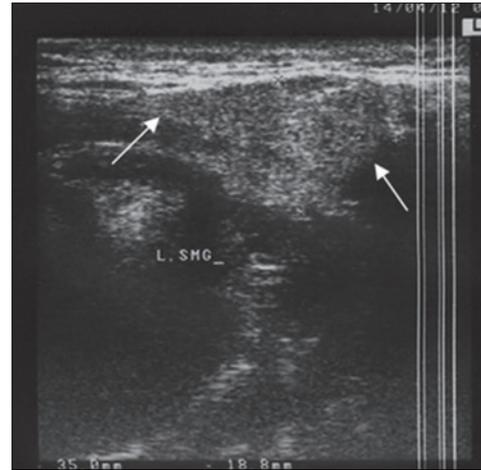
Ultrasonographic view of submandibular gland of a 33 years old patient. Mild non homogeneity and hyperecho parenchyma is visible
